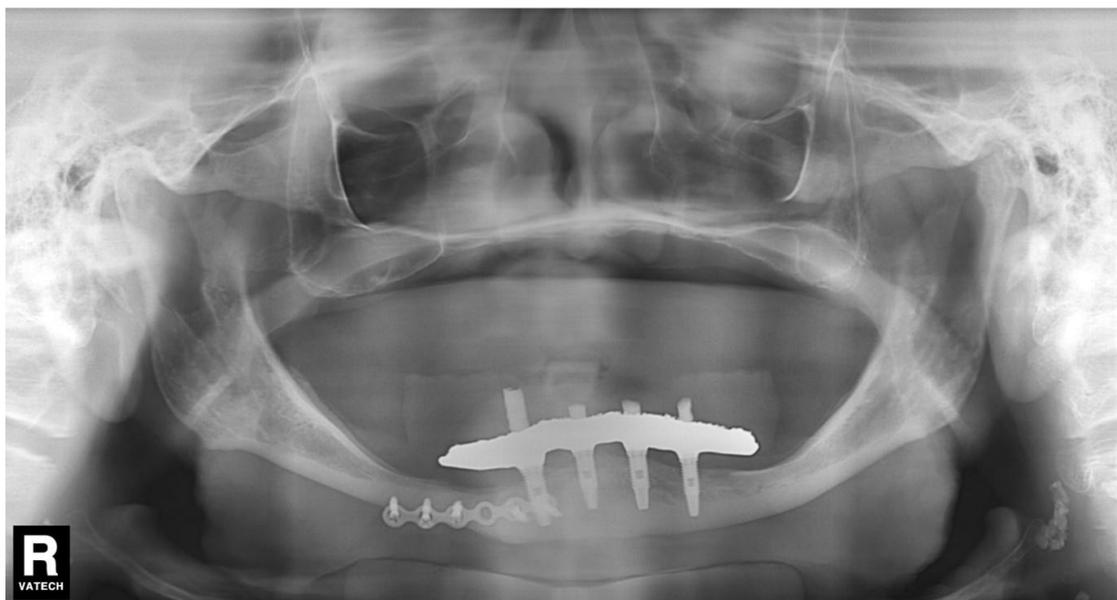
a. Extraoral anesthesia; 3b. Buccal access for bone exposure; 3c. Use of load-sharing system plate for fixation of the fracture and stabilization; 3d. Immediate panoramic radiography after plate placement.
